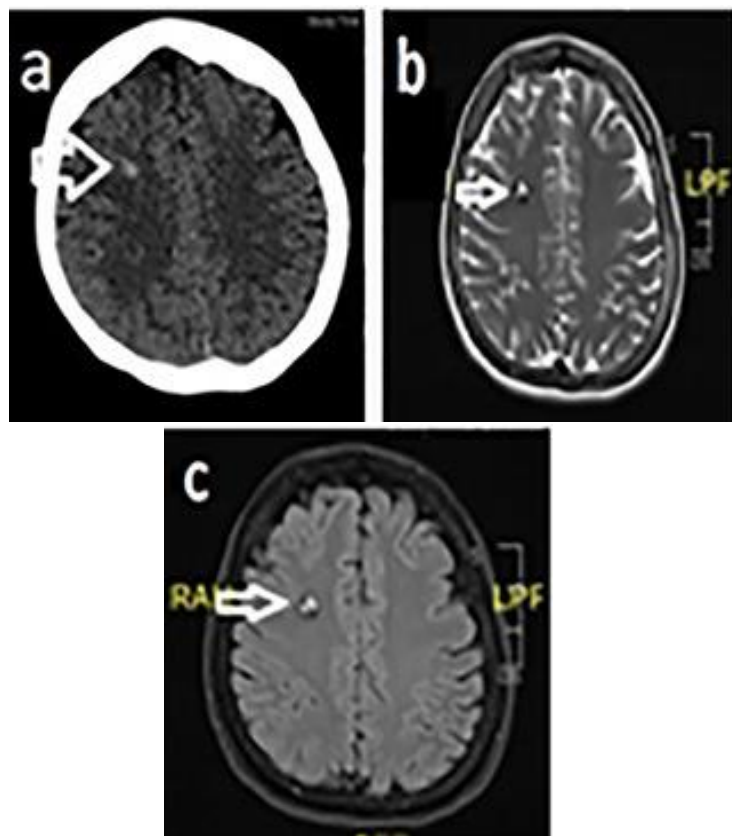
(a) CT brain showing hemorrhage in the right frontal region. T2 axial (b) and FLAIR axial (c) section of MRI brain showing hemorrhage related with cavernous hemangioma in the right frontal lobe.
